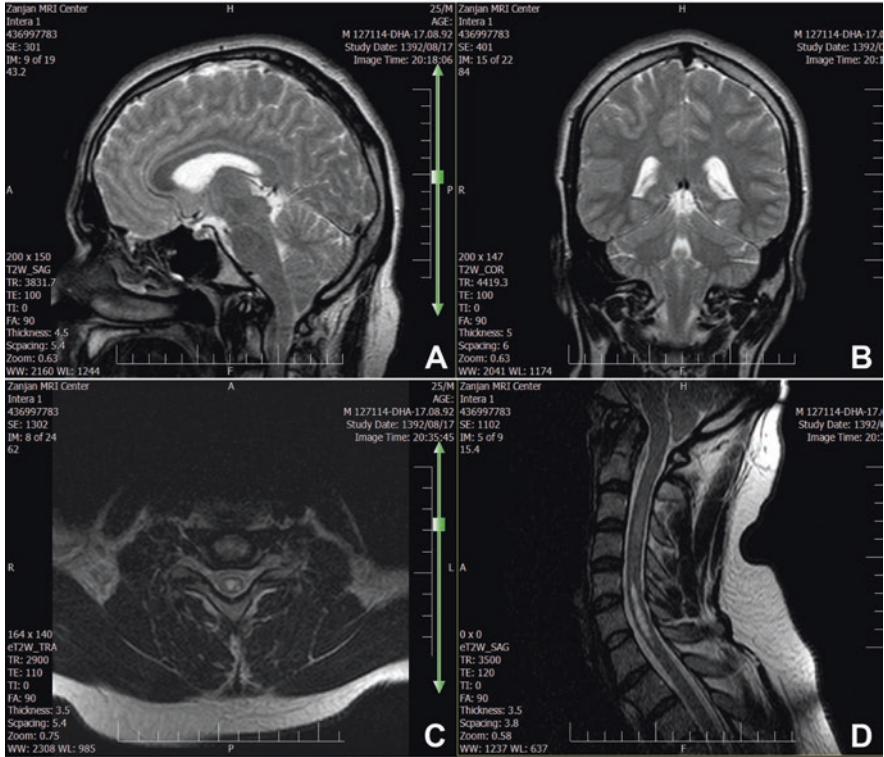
Chiari malformation type I. (a, b) Sagittal and coronal T2-weighted brain MR images. There is slight inferior herniation of cerebellar tonsils through the foramen magnum that is less than 5 mm and shows benign tonsillar ectopia that could be a mild variant of Chiari malformation. (c, d) Axial and sagittal T2-weighted MR images of the brainstem and cervical spinal cord. Note the presence of a large syrinx in association with tonsillar ectopia in Chiari malformation type I
